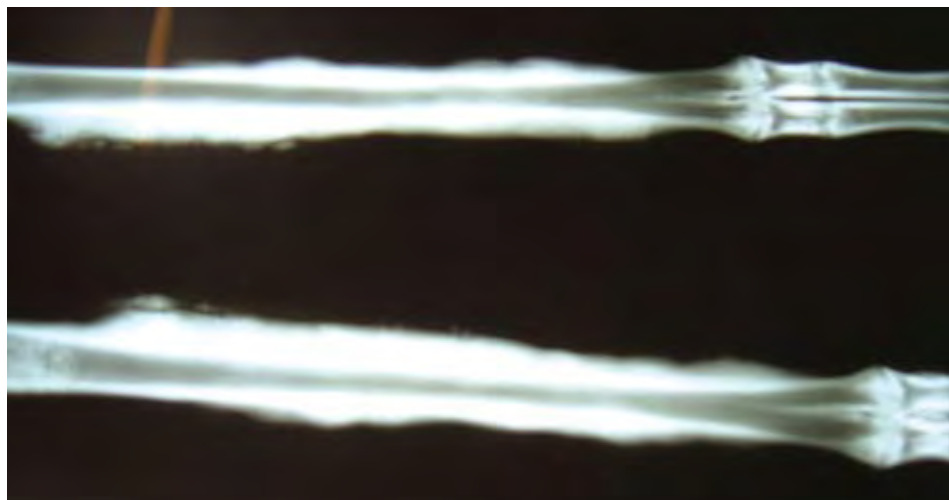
Dorso-ventral radiograph of metacarpus from a gerenuk (*Litocranius walleri*) antelope showing periosteal proliferation
